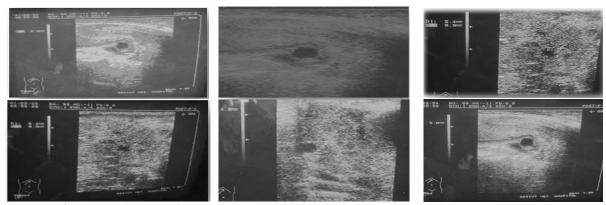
The follicular diameters in ovarian ewes by ultrasonography.
